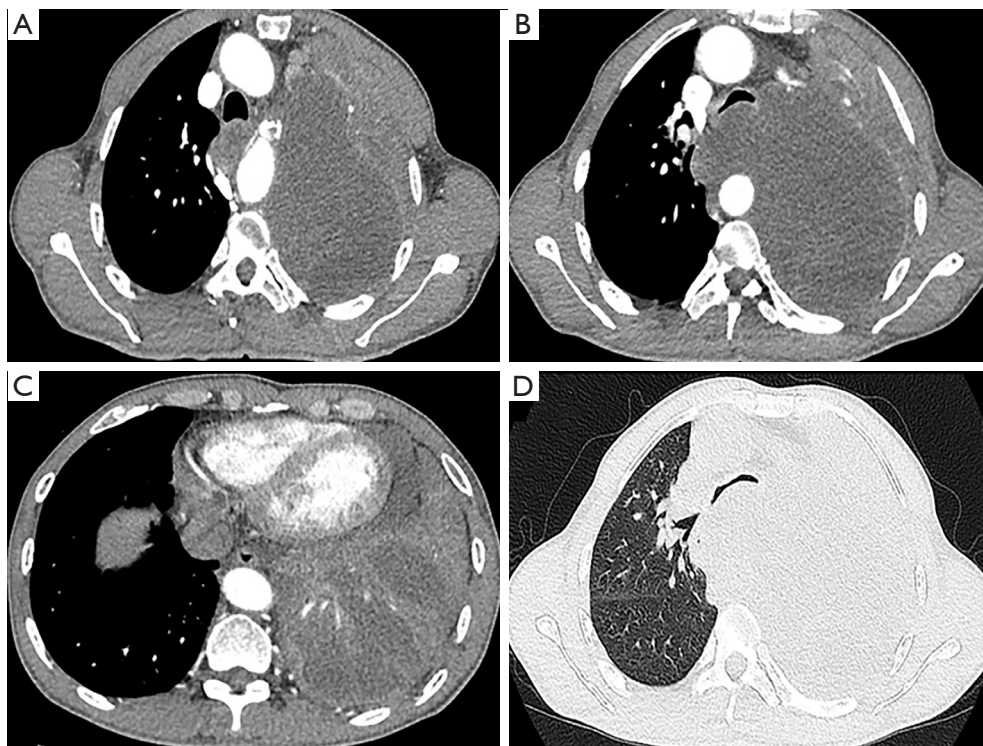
CT imaging findings. (A-D) Show the CT images: plain CT scan of the posterior mediastinum and the left thoracic cavity of the patient showed a large solid cystic space-occupying lesion with a size of approximately $14.8 \times 10.7 \times 18.5 \text{ cm}^3$, thin-walled with no visible mural nodules. A contrast-enhanced CT scan showed that the cyst wall was significantly enhanced, whereas the cystic part was not. The cyst wall and the intrathoracic mass were enhanced to different degrees, with the latter being mildly enhanced, and pathological examination confirmed it as the undeveloped left lung. The adjacent trachea, esophagus, left lung, and left lung arteries and veins were compressed and narrowed, and the boundaries were not clear. Additionally, atelectasis of the left lung, rightward deviation of the mediastinal structure, and multiple enlarged lymph node shadows in the left upper mediastinum and near the hilum of the left lung were observed. No exact abnormal density shadow was seen in the anterior mediastinum. Imaging and gastrointestinal endoscopy did not reveal abnormalities in other systems, such as the gastrointestinal tract and the urinary tract. CT, computed tomography.
